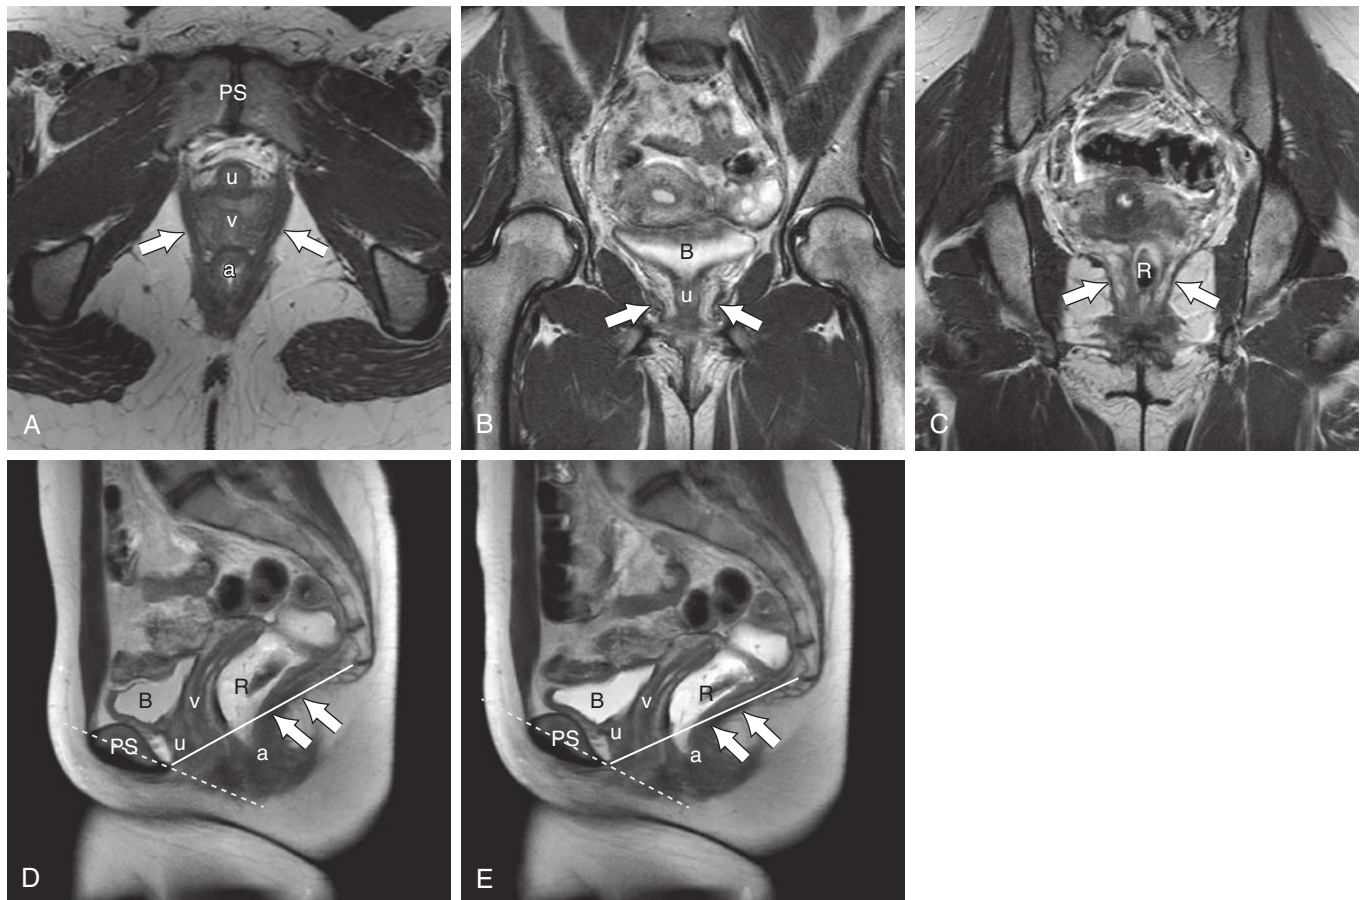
Normal pelvic floor structures on magnetic resonance imaging (MRI). Dynamic T2-weighted MRI of asymptomatic normal subject. A, Axial T2-weighted image shows symmetric appearance of bilateral levator muscles (*block arrows*) inserting onto the pubic bones. B, Coronal image at the level of the insertion bones shows symmetric levators as well. C, Coronal image at the level of the rectum shows normal levators (*arrows*). D, Sagittal T2-weighted image shows normal position of the bladder, vaginal apex, and posterior plate of the rectum (*block arrows*) above the pubococcygeal line (PCL), a representation of the pelvic floor. E, With strain, there is little descent of these organs, which remain above the PCL line (*block arrows*). a, anal canal; B, bladder; dotted line, midpubic line; PS, pubic symphysis; R, rectum; u, urethra; v, vagina.
